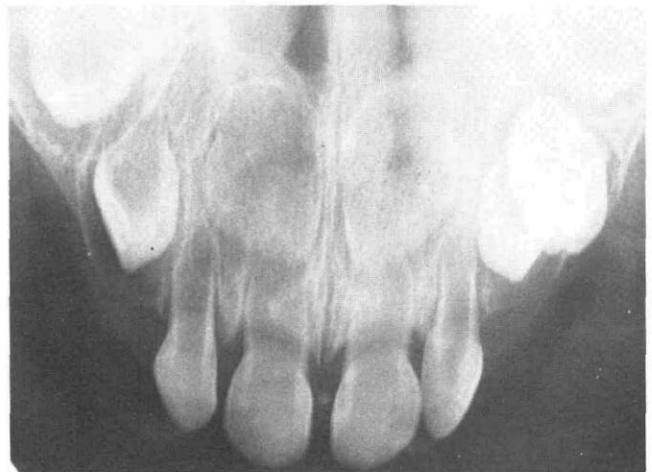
Occlusal radiograph of the patient at age nine months. The maxillary left primary first molar is visible but the right is missing.
